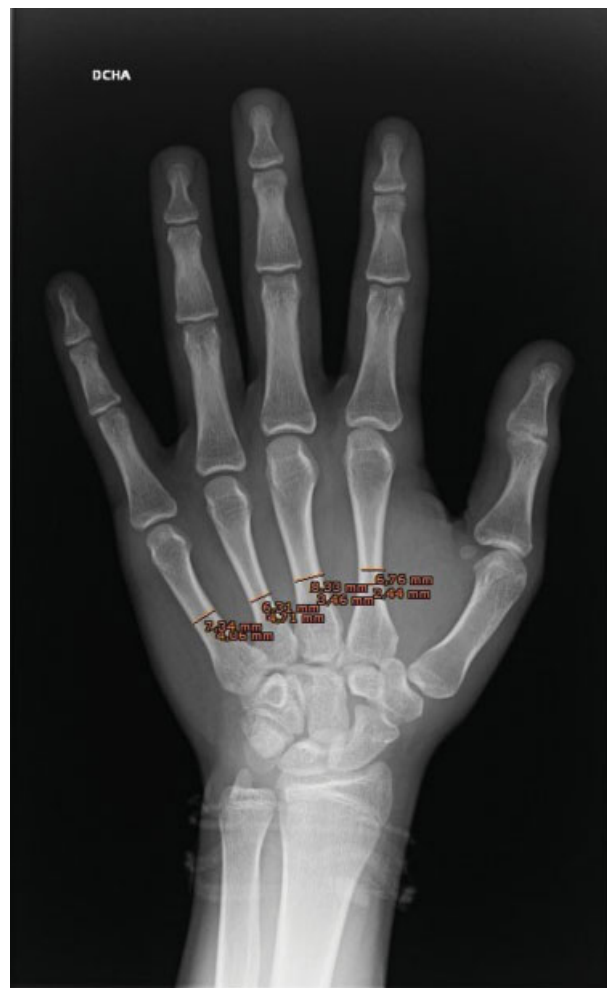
Measurement of the metacarpals of the large fingers on PA radiograph using IRE Image Channel software (IRE Rayos X S.A., Madrid, Spain).
